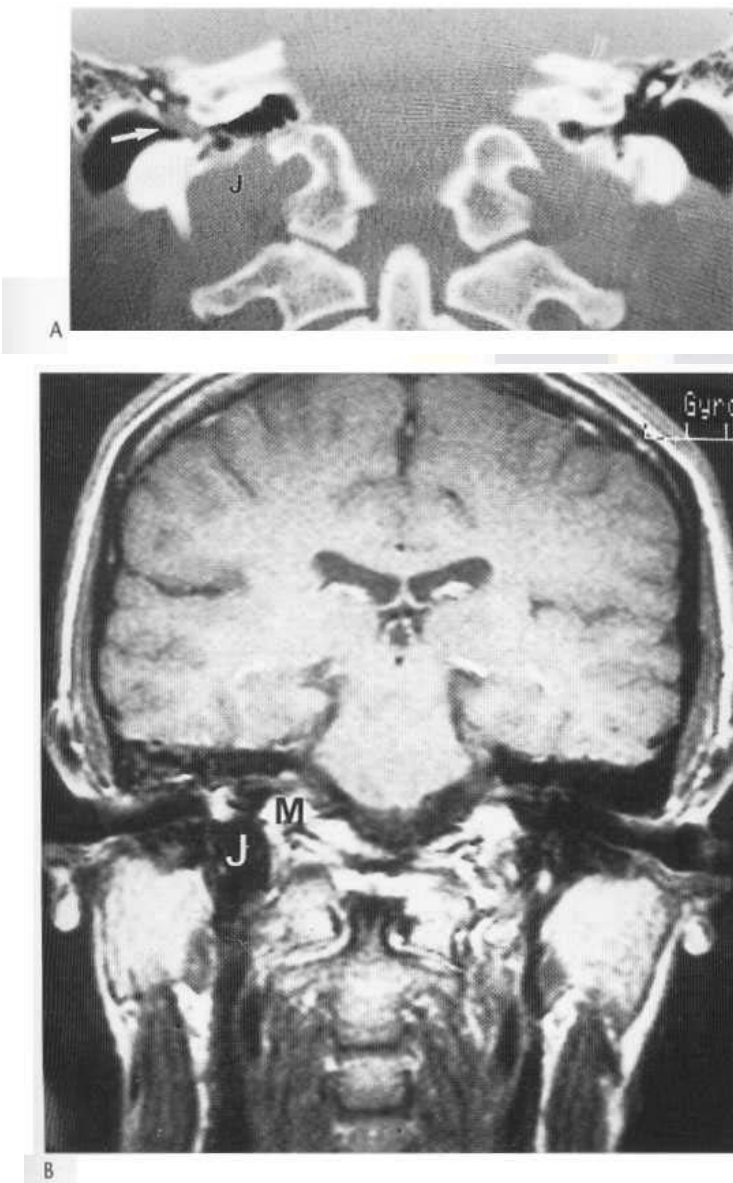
(A) Coronal CT showing a small glomus tympanicum in the lower middle ear cavity (arrow). J = jugular bulb. (B) An equivalent MR section confirms that this is quite separate from flowing blood in the jugular bulb (J). Note the confusing proximity of marrow fat (M).
